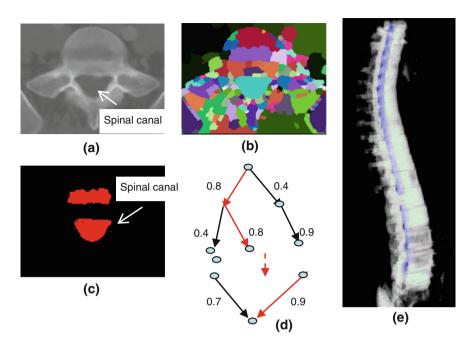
Spinal canal extraction. a CT image; b watershed result; c spinal canal candidates; d directed acyclic graph (DAG), number on the edge is the weight between two nodes; and e extracted spinal canal (*blue color*)
